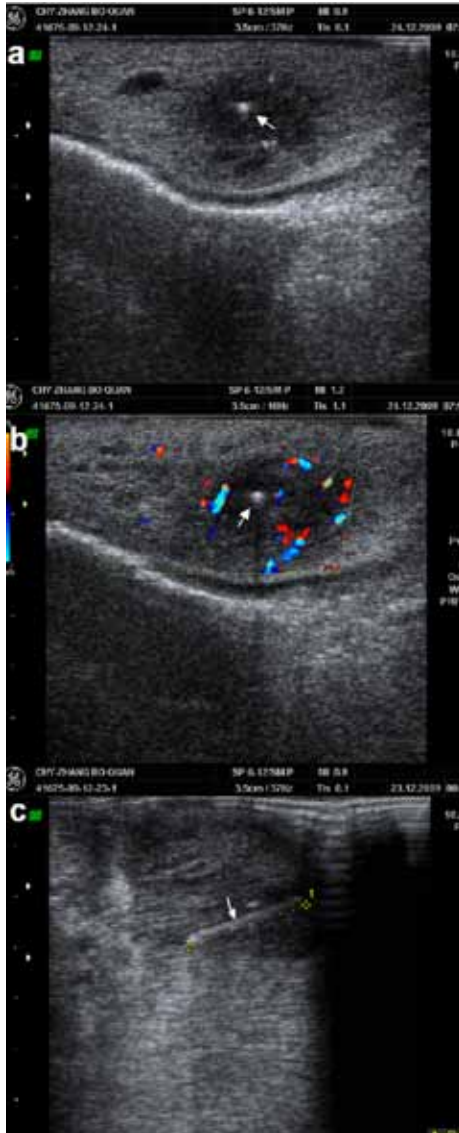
Ultrasound images of the tongue mass. a The tongue mass showed a hypoechoic region (1.7 × 1.0 cm) with a hyperechoic spot. b The tongue mass showed a rich blood supply and irregular margin. c Ultrasound showed a linear foreign body-like hyperechoic area (1.2 × 0.07 cm) at the edge of the mass.
